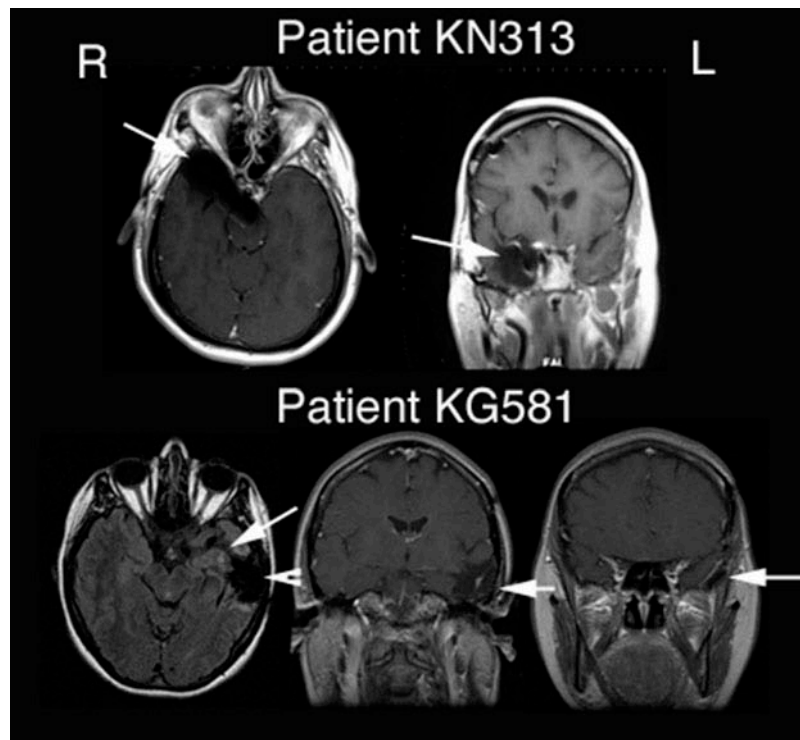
MRI scans from the two patients tested in this study. Scans are shown in radiological convention (e.g. left on the right). Patient KG581's scans are FLAIR images (axial view) or T2-weighted images (coronal view). The resection is clearly evident. More subtle damage from post-surgical changes, including scarring and residual tumor, are also evident.
